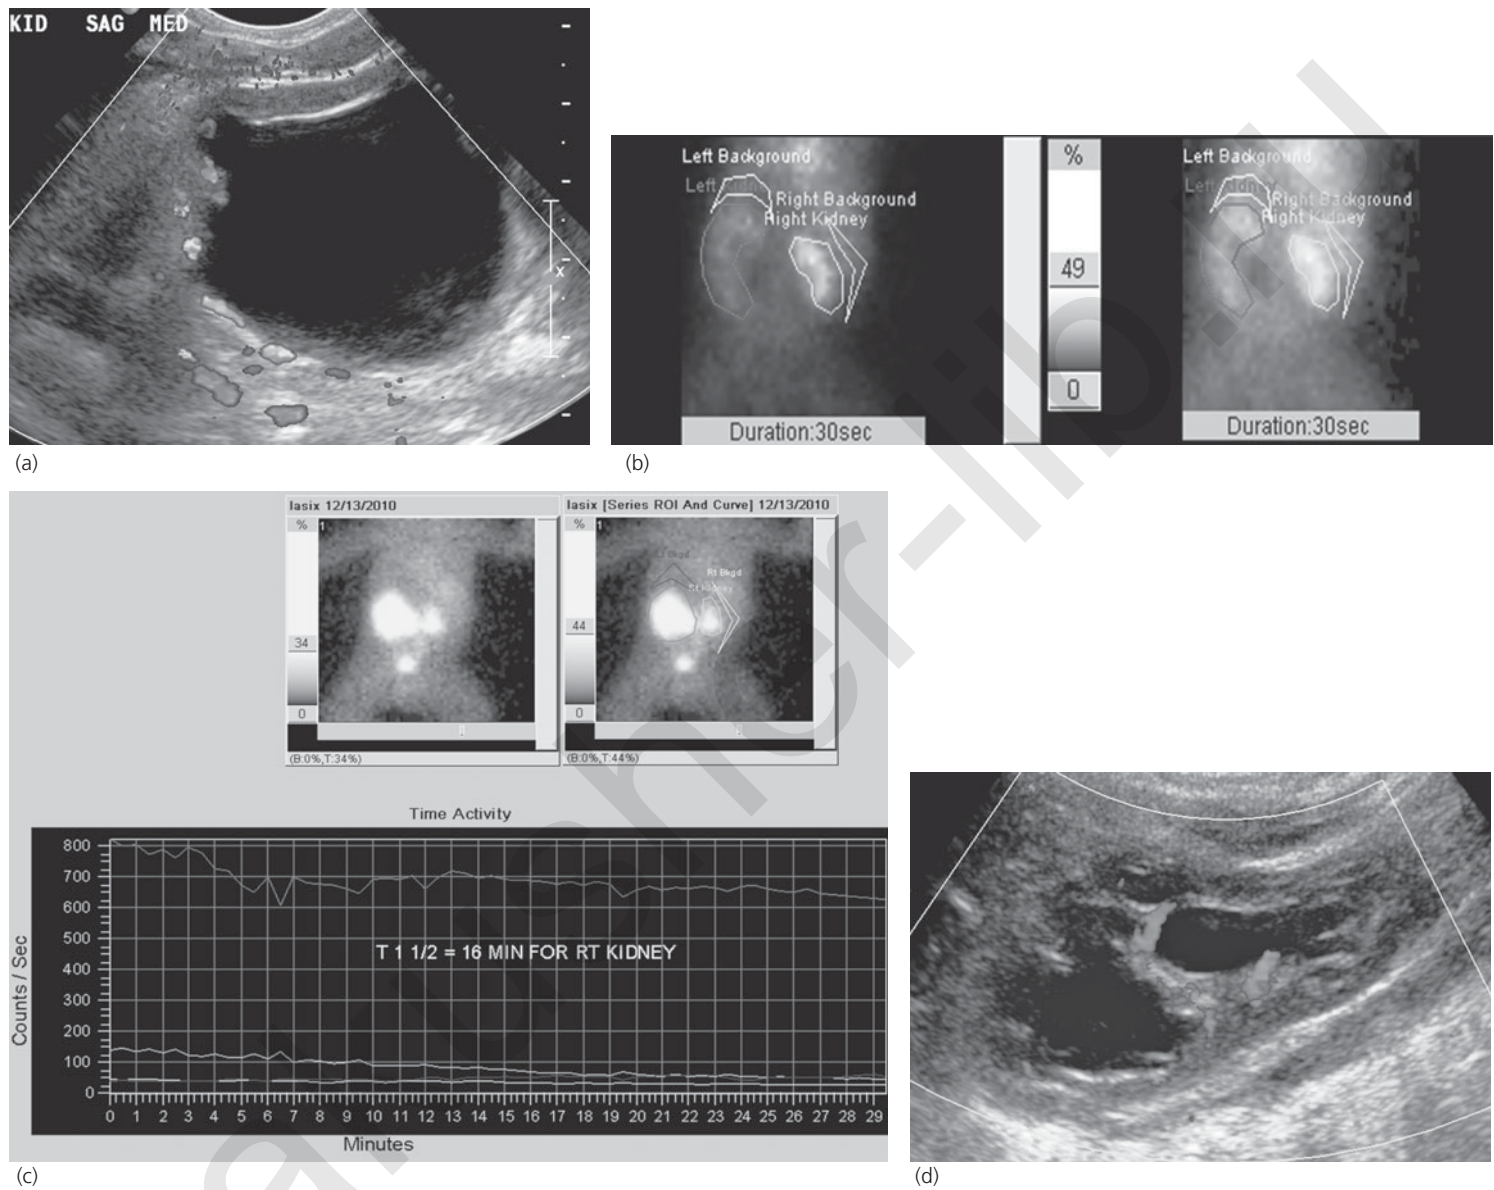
Newborn with prenatal diagnosis of left hydronephrosis. (a) Sonogram left kidney demonstrates grade 4 left hydronephrosis without a dilated ureter. The voiding cystourethrogram was normal. (b,c) MAG-3 diuretic renogram (left kidney on the left side of image) shows minimal drainage on the left side. The differential function left:right was 46:54%. Patient underwent left pyeloplasty at two months of age. (d) Follow-up sonogram of left kidney at five months of age demonstrates reduction in hydronephrosis.
